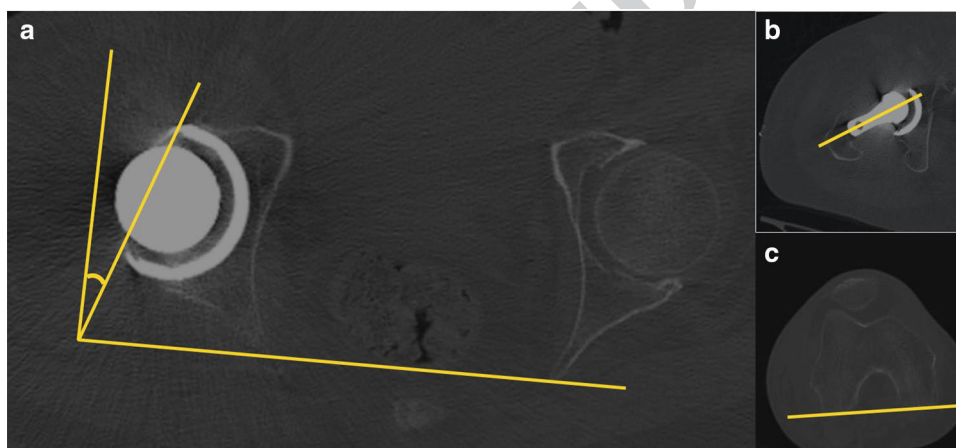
Technique for CT measurement of acetabular and femoral component version according to Fujishiro et al. a Acetabular component version is measured between a line joining the lateral AP margins of the socket and the sagittal plane, measured as a perpendicular to a line connecting two identical points on either side of the pelvis.
